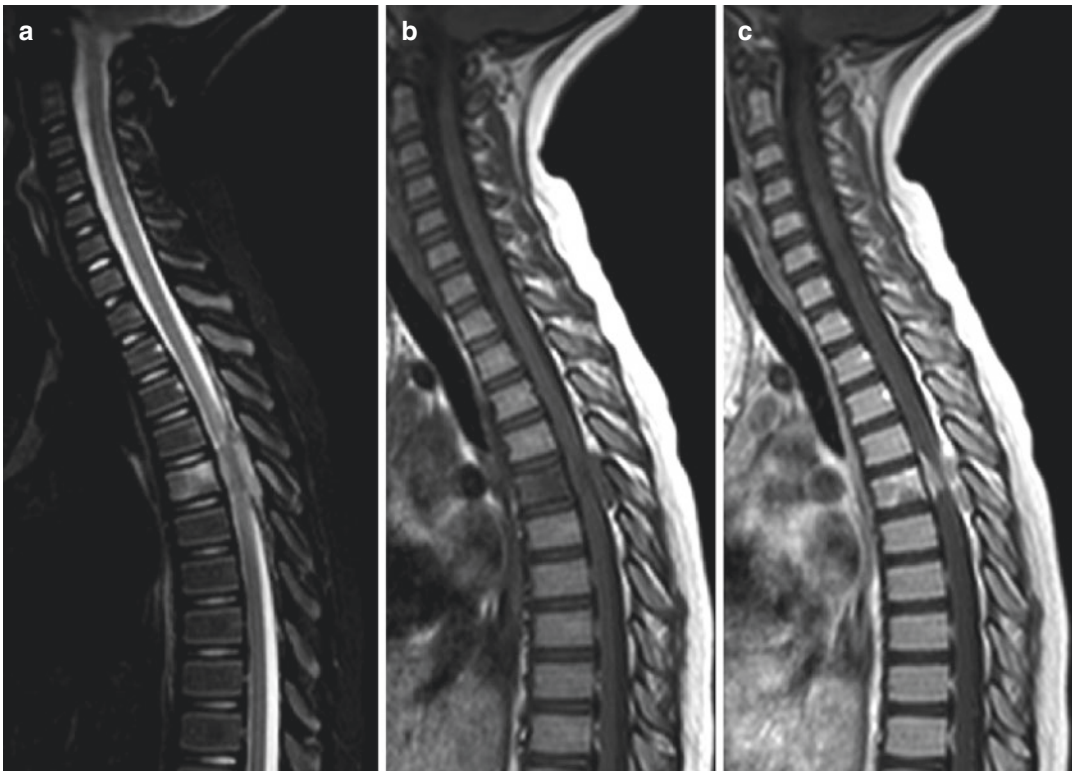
Spinal compression. Sagittal T2-weighted fat-suppressed (a), T1-weighted (b), and gadolinium-enhanced T1-weighted (c) of the cervicothoracic spine
